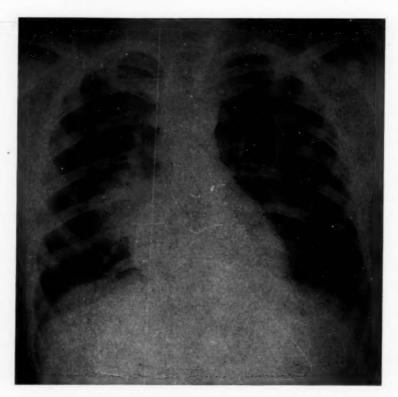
Chest roentgenogram showing right parahilar mass.
